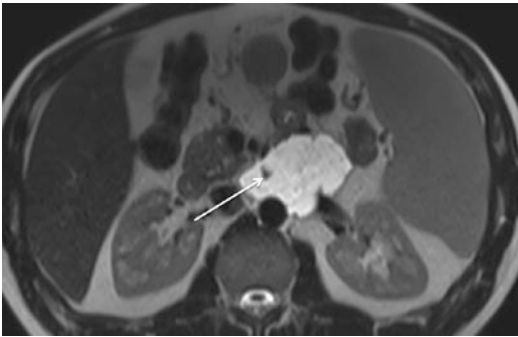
T2-weighted MRI shows a multiloculated T2 hyperintense lesion with thin wall consistent with a lymphangioma (white arrow)
